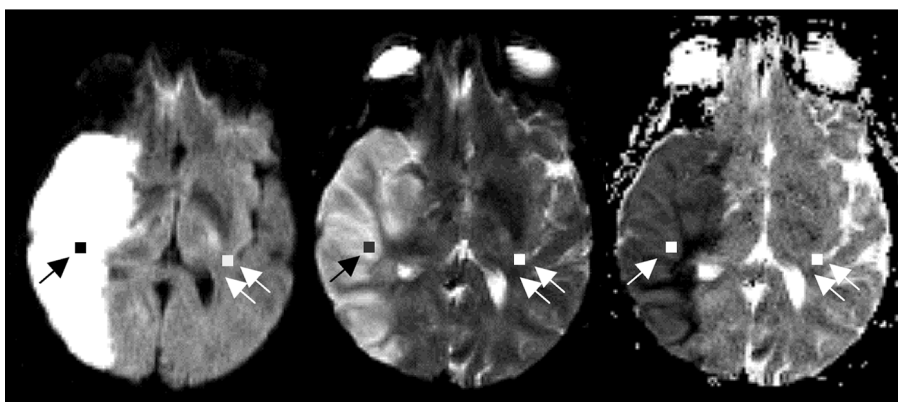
Transverse isotropic diffusion-weighted MR image (left), MR image obtained with low b value (middle), and ADC map (right) in a 51-year-old woman examined 32.6 hours after stroke onset. Note the ROIs (single arrow) placed on the lesion and normal-appearing tissue (double arrows) in the contralateral hemisphere.
